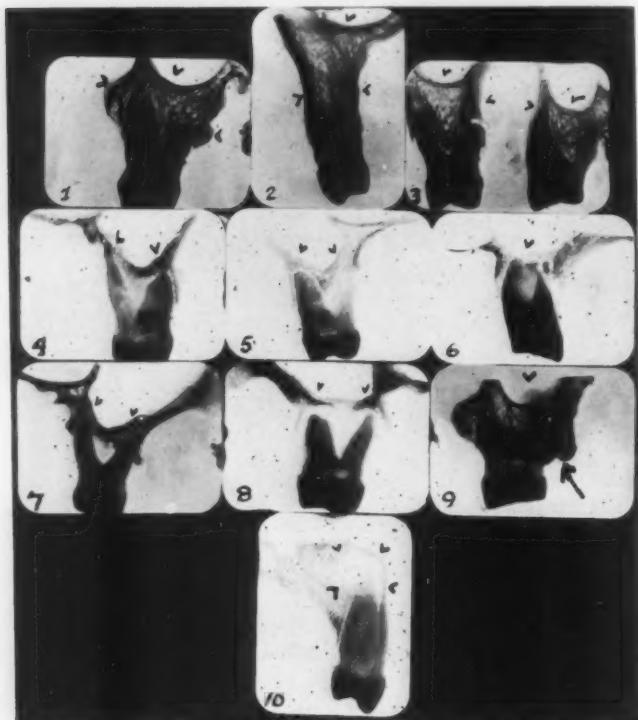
X-rays of longitudinal sections depicting the proximity of the roots to the antrum. (1-2-3) Relatively normal bone; the roots are a considerable distance from the floor of the antrum. (4-5-6-7-8) The roots are either very close to or entering the floors of the antrums. The necrosis of bone involves the walls and floors of the antrums. The bifurcations of the roots are large receptacles, which retain decomposed waste material, food debris, pus, etc. (9) Embedded tooth with root projecting into the antrum. (10) Granuloma, causing considerable destruction of bone leading toward the antrum.
